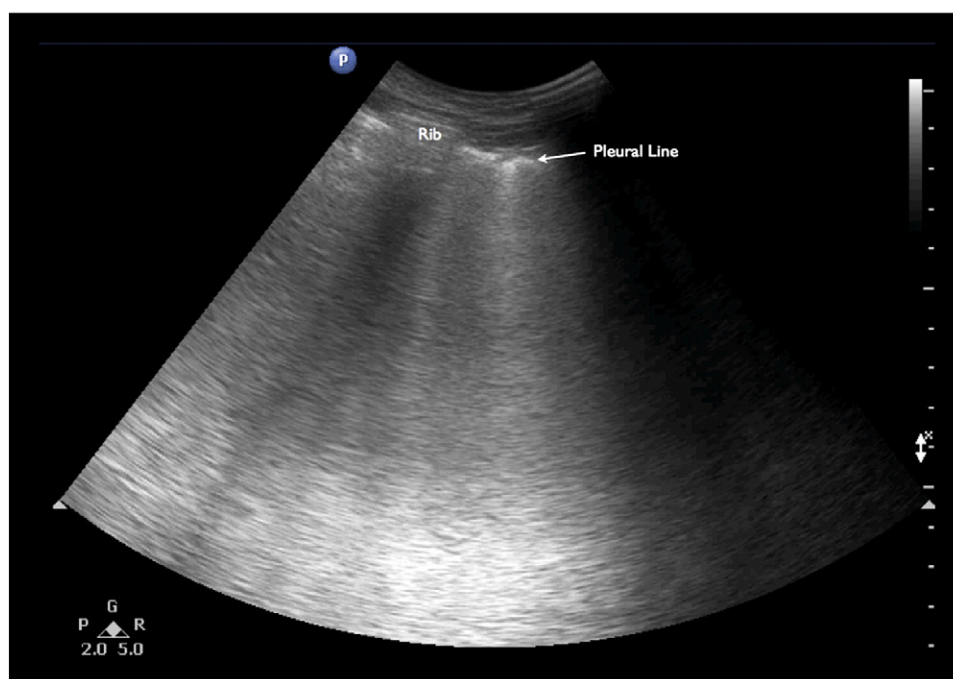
Lung ultrasound. Diffuse B-lines arising from the pleural line bilaterally, pathognomonic for AIS that includes cardiogenic pulmonary edema, ARDS, or interstitial pneumonia.
